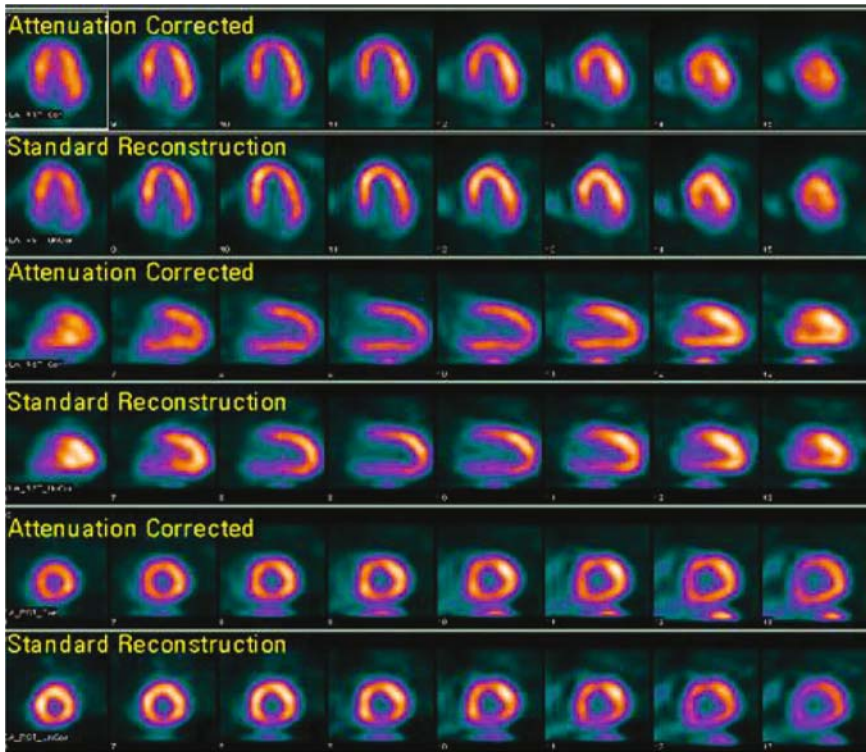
Myocardial perfusion scans acquired with GE Discovery VG using x-ray derived attenuation map. In each pair of rows, the top and bottom rows represent data reconstructed with and without attenuation correction respectively. In this study, the patient presented with chest pain with borderline normal ejection fraction of 47%. Resting  $^{99m}\text{Tc}$ -sestamibi perfusion scan without attenuation correction shows mild inferior wall defect. However, myocardial perfusion images appear normal when reconstructed with x-ray based attenuation correction. Reprinted with permission from GE Healthcare Technologies, Waukesha, WI.
